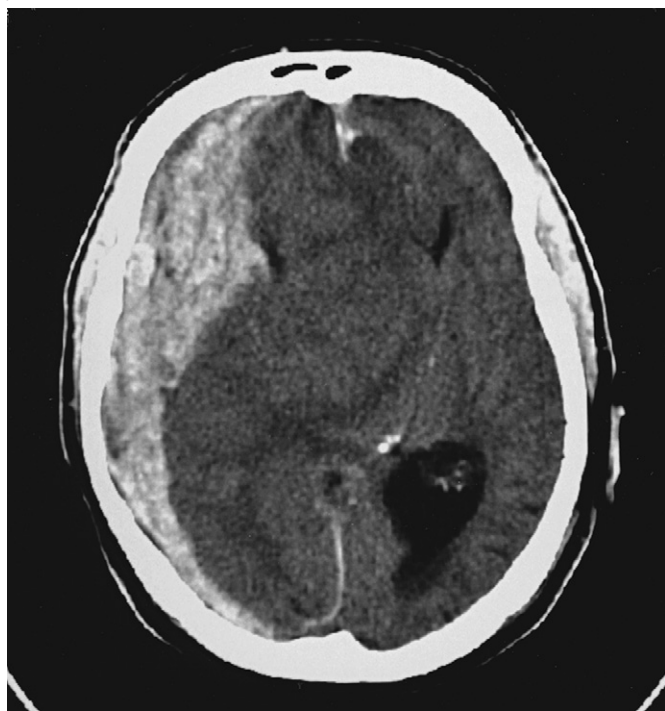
Non-contrast-enhanced computed tomography scan of acute right temporal subdural hematoma. There is acute bleeding as well as delayed bleeding, which explains the mixed density. Mass effect is large, with midline shift measuring approximately 2.7 cm right to left. The right lateral ventricle has been obliterated.
